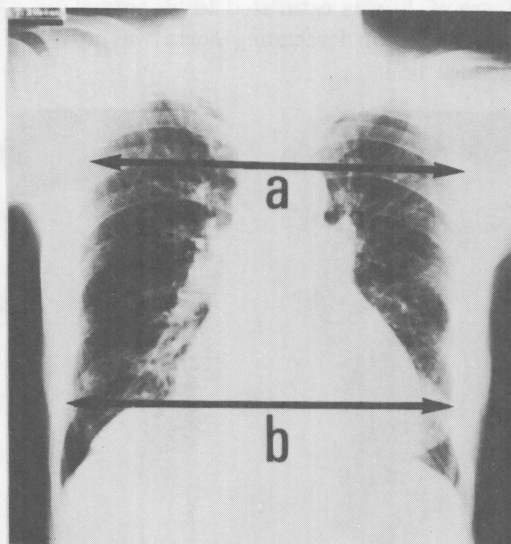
The typical radiograph of “senile lung”
